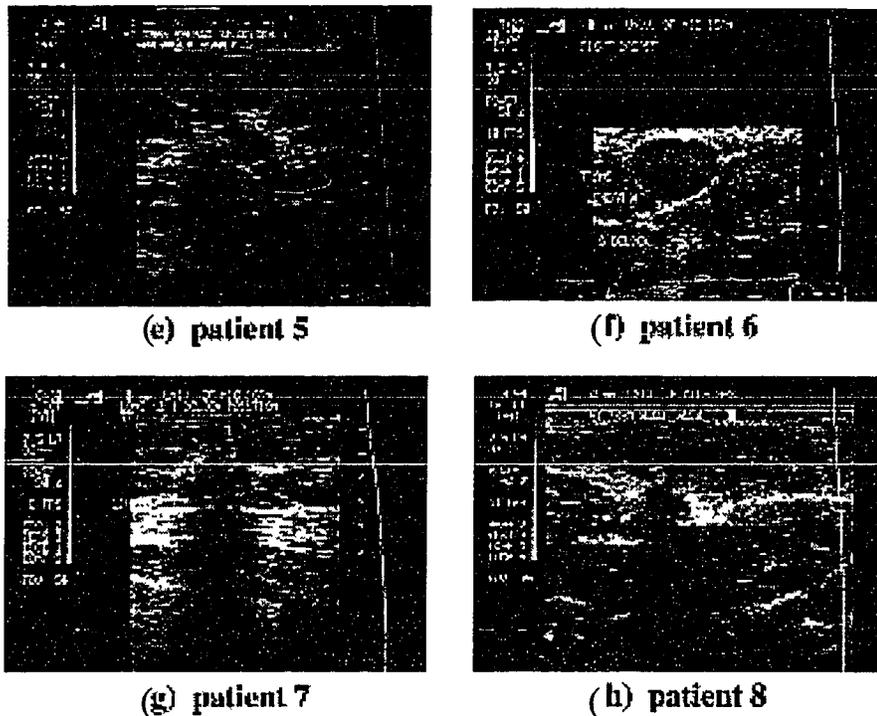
Ultrasound images for patients 5-8.
